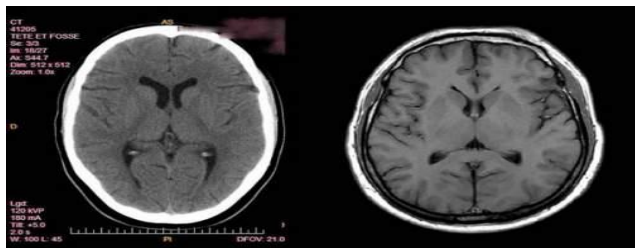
MRI and CT image modalities
